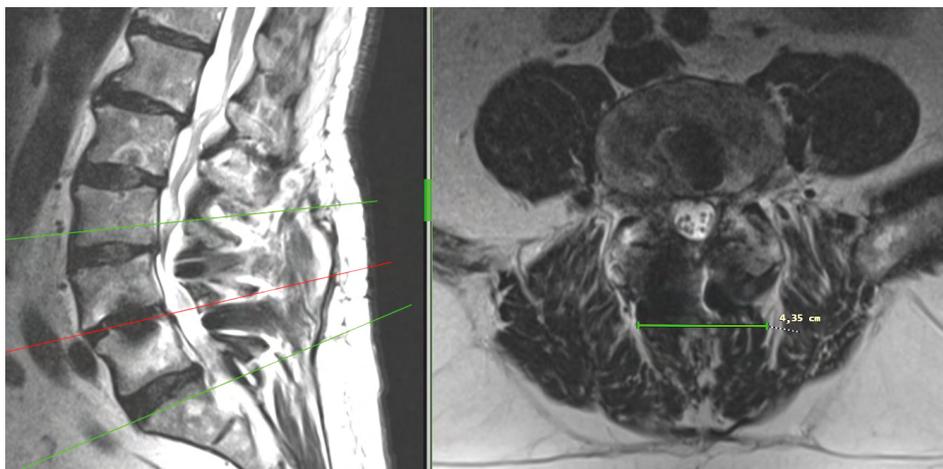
Postoperative T2-weighted MRI scan of a patient after MIDLF/CBT in L4/5 due to spondylolisthesis – measuring bilateral width of multifidus muscles in the operated segment
